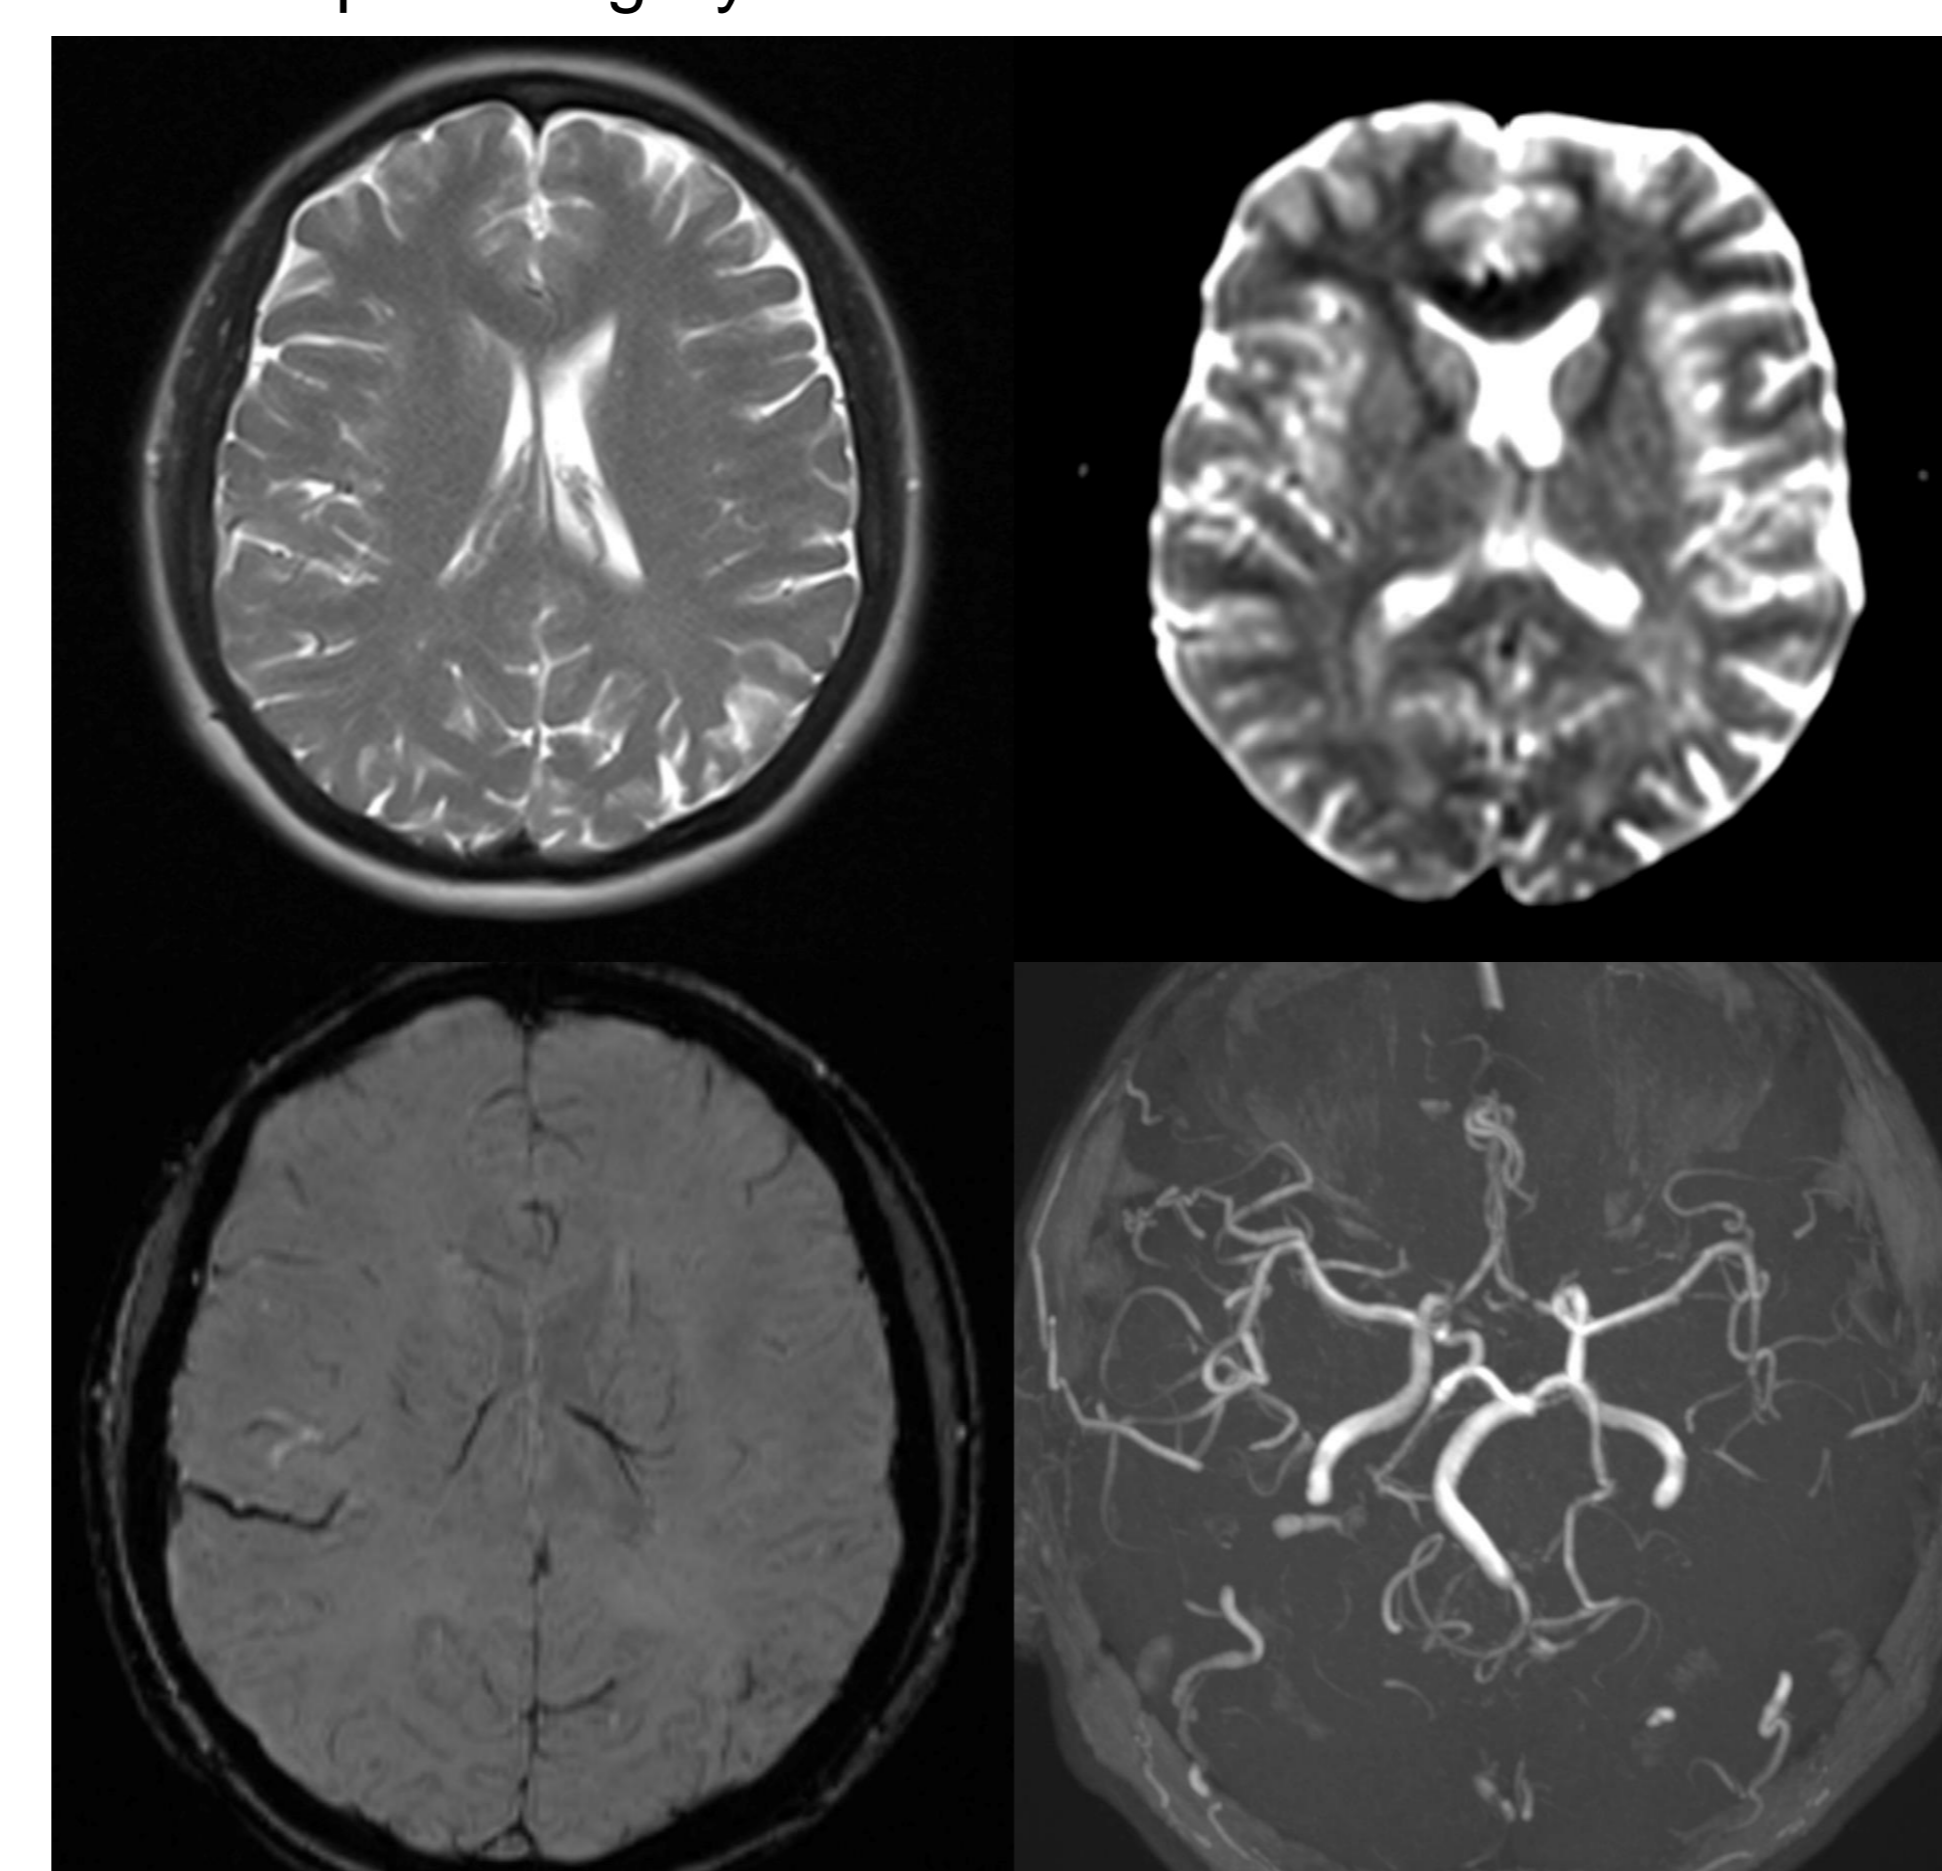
Results of the brain MRI on the 7th day after surgery show no signs of ischemia or hemorrhage as a cause of the neurological symptoms that developed.
